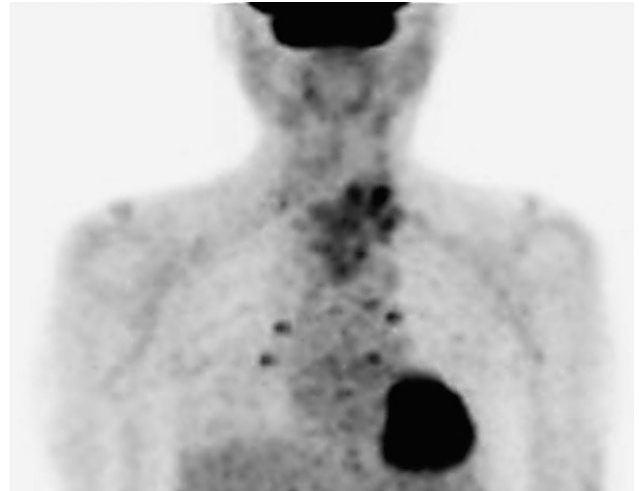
PET/CT image shows the heterogeneous accumulation of FDG in the tumor (SUV-max: 7.77).
